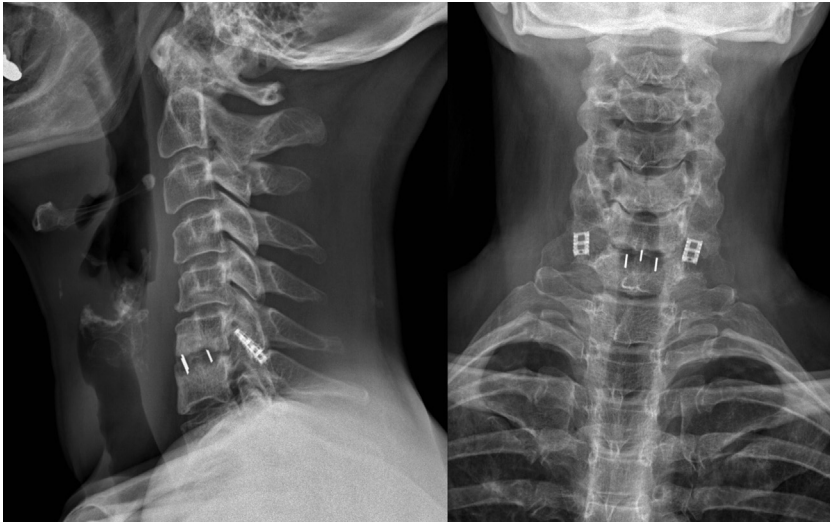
A 45-year-old woman was treated with anterior cervical discectomy and fusion for a left disc herniation. After 6 months she reported recurrence of radiculopathy. Radiographs showed intersomatic pseudarthrosis. Cervical interfacet spacers were then successfully used to obtain relief from the radicular impingement.
